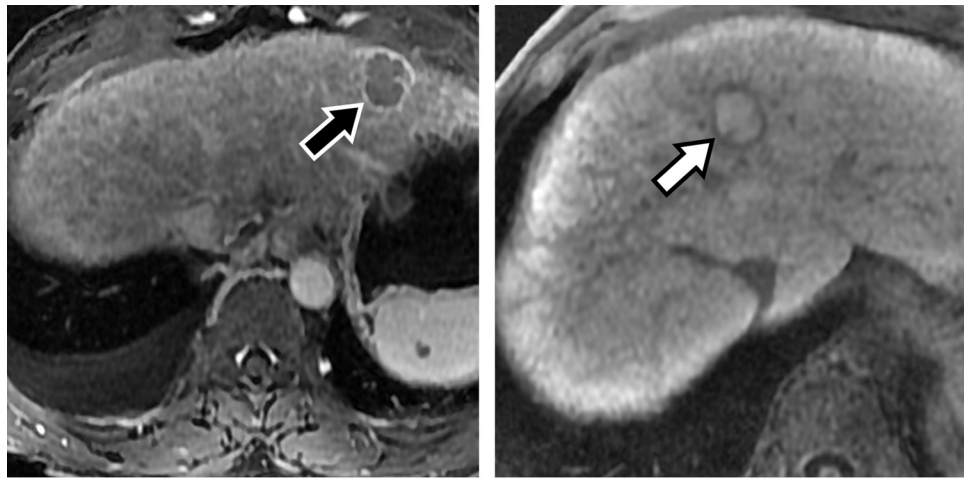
Capsule in a 63-year-old woman (a) and 54-year-old man (b), each of whom has an LR-5 (definitely HCC) lesion. (a) Axial delayed phase MR image shows an enhancing capsule (arrow). (b) Axial hepatobiliary phase MR image shows a nonenhancing capsule (arrow).
